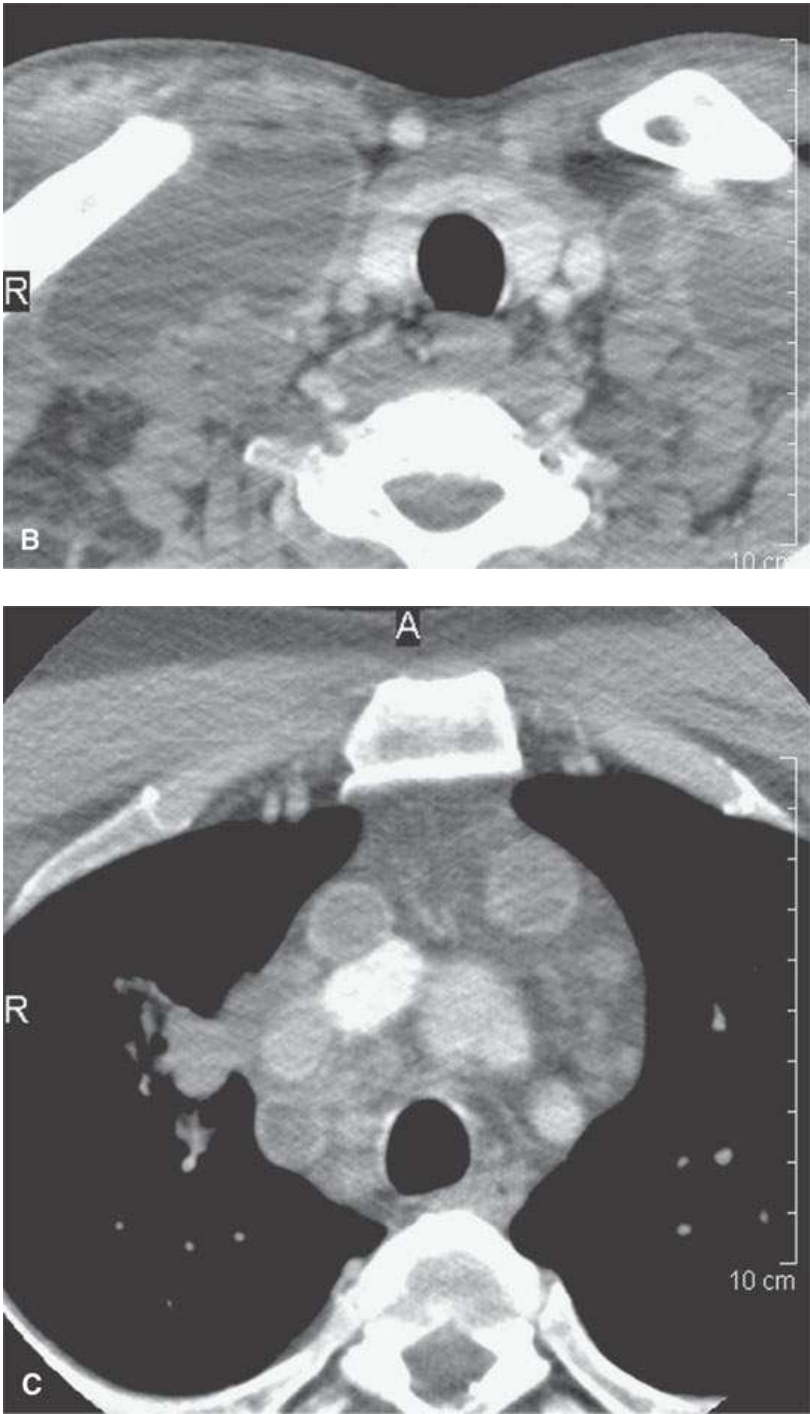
Contrast-enhanced computed tomography of an HIV-positive patient with bilateral neck masses. A–C: Multiple, bilateral cystic masses and obviously mediastinal adenopathy. The walls of the nodes enhance minimally, and there is a relatively low grade inflammatory response surrounding the nodes in both the neck and the mediastinum.
